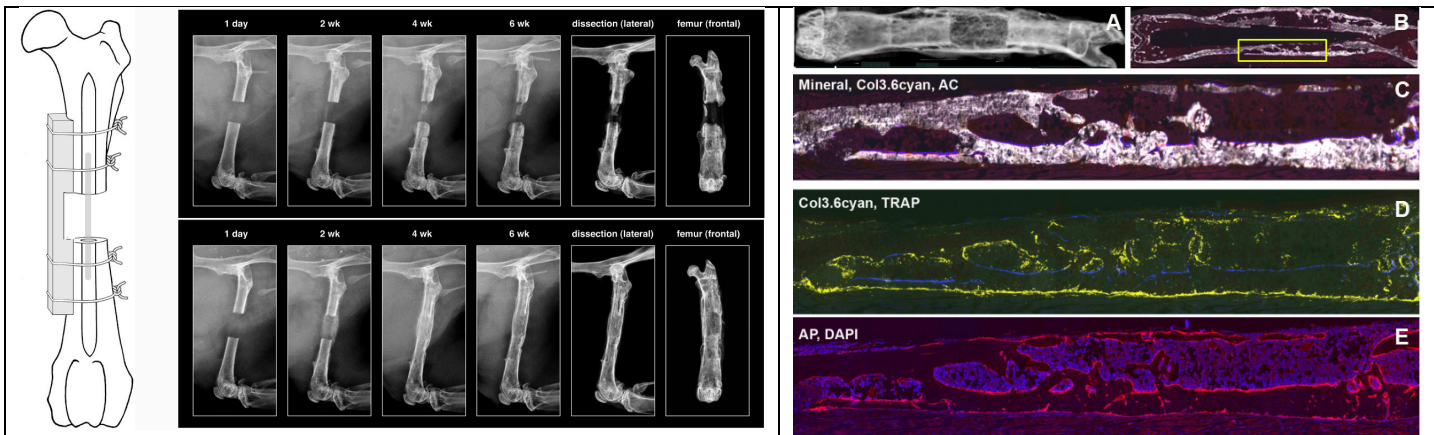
Rigid fixation for a critical sized segmental defect of the femur. The X-ray progression over 6 weeks post surgery show the requirement for competent BMSC for healing the defect (top vs bottom row).
